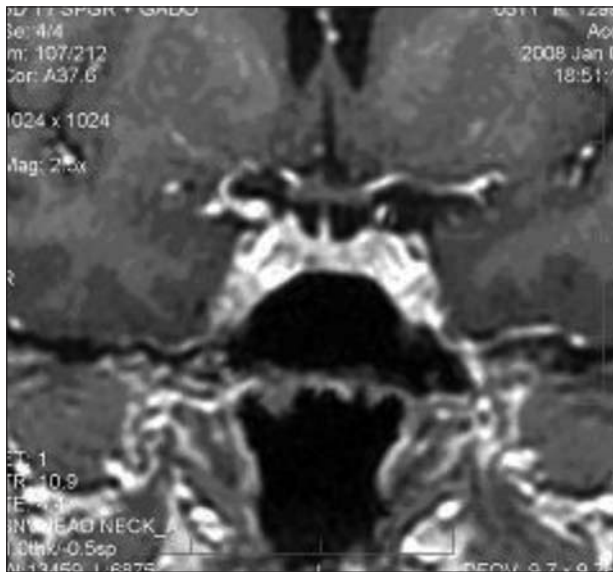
Three-dimensional SPGR MR image exhibiting a 0.4 × 0.3-cm posterolateral right-sided pituitary microadenoma (arrow). Pituitary stalk with slightly asymmetric implantation corresponding to the anatomic variable is observed.
